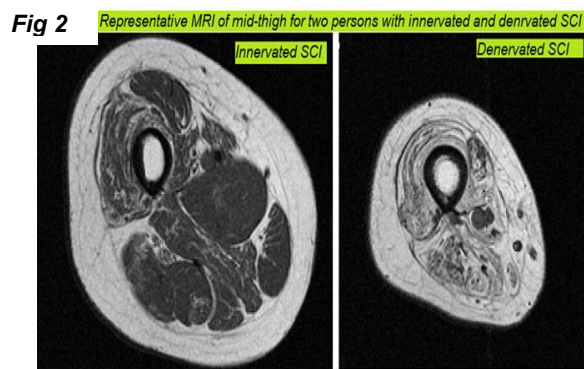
Representative MRI of mid-thigh for two persons with innervated and denervated muscles after SCI.
